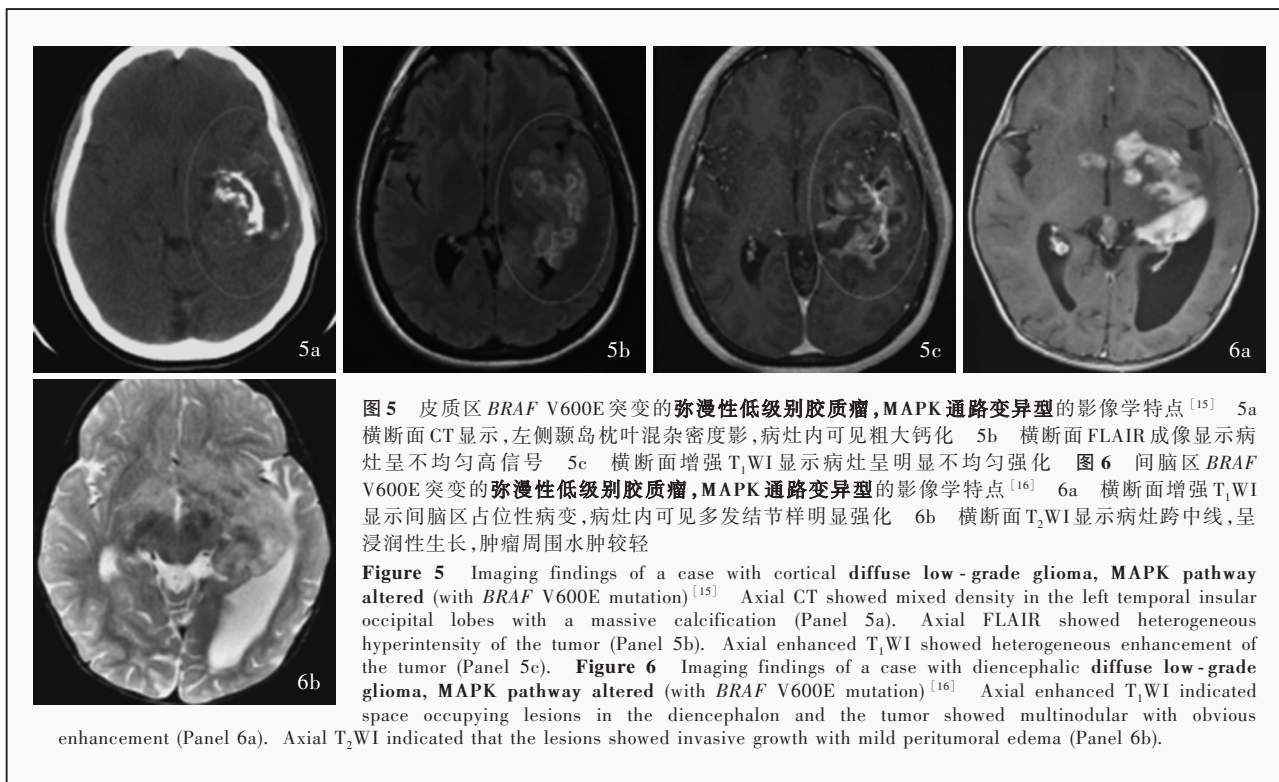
皮质区 *BRAF* V600E 突变的弥漫性低级别胶质瘤, MAPK 通路变异型的影像学特点<sup>[15]</sup> 5a 横断面 CT 显示, 左侧颞岛枕叶混杂密度影, 病灶内可见粗大钙化 5b 横断面 FLAIR 成像显示病灶呈不均匀高信号 5c 横断面增强 T<sub>1</sub>WI 显示病灶呈明显不均匀强化 图6 间脑区 *BRAF* V600E 突变的弥漫性低级别胶质瘤, MAPK 通路变异型的影像学特点<sup>[16]</sup> 6a 横断面增强 T<sub>1</sub>WI 显示间脑区占位性病变, 病灶内可见多发结节样明显强化 6b 横断面 T<sub>2</sub>WI 显示病灶跨中线, 呈浸润性生长, 肿瘤周围水肿较轻
